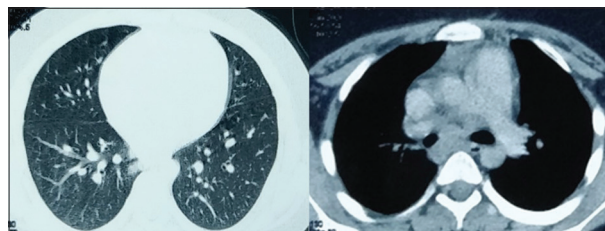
Representative Computed tomography sections
